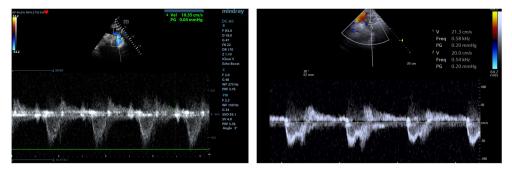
b.18. Evaluation of the end diastolic velocity of the aortic flow regurgitation jet in descending aorta (suprasternal view, color and PW Doppler) in a case of moderate (V = 10.3 cm/s) (left) and severe (right) aortic regurgitation (V = 21.3 cm/s)
